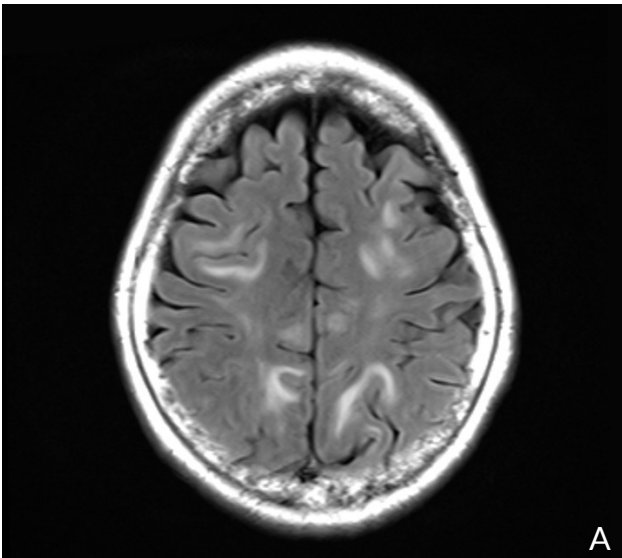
(A): Magnetic resonance imaging showing symmetric bilateral cortical and subcortical hyperintensities on T2-fluid-attenuated inversion recovery images predominantly in the occipital lobes, parietal lobes, and part of the frontal lobes. (B): After 3 months, magnetic resonance imaging showing the disappearance of the area of hyperintensities on T2-fluid-attenuated inversion recovery images.
